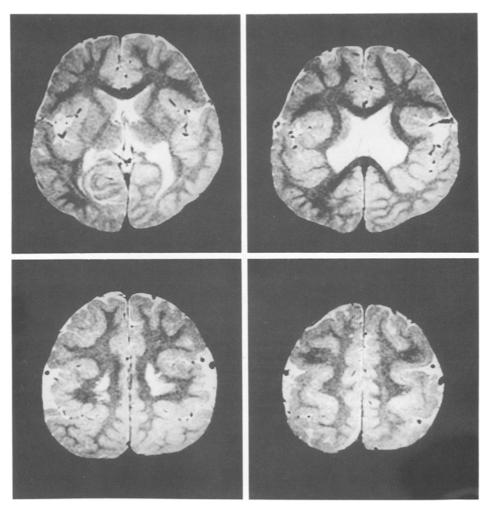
T2-weighted images (TR=3,000 ms, TE=80 ms) of cranial MRI.
